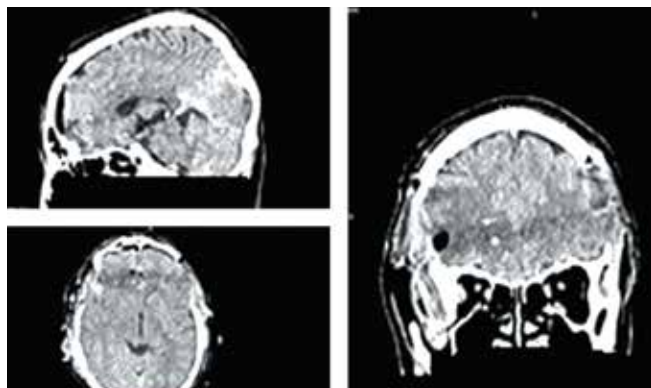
Computed tomography of patient N. after surgery: hemorrhages along the wound canal; no midline brain shift; no brain edema
